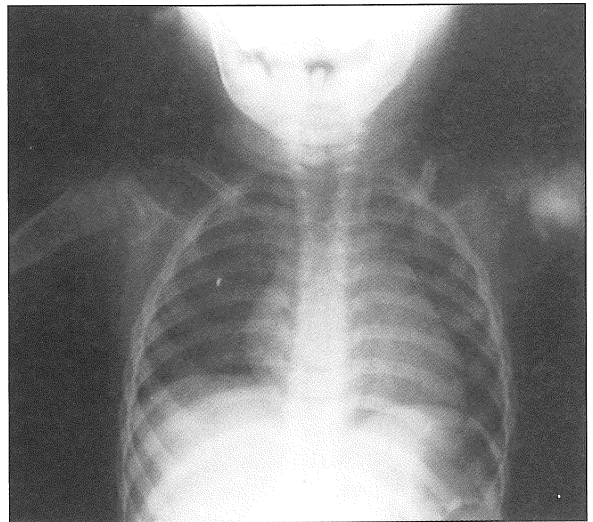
Plain X-ray showing the lesion in the left proximal humerus.
